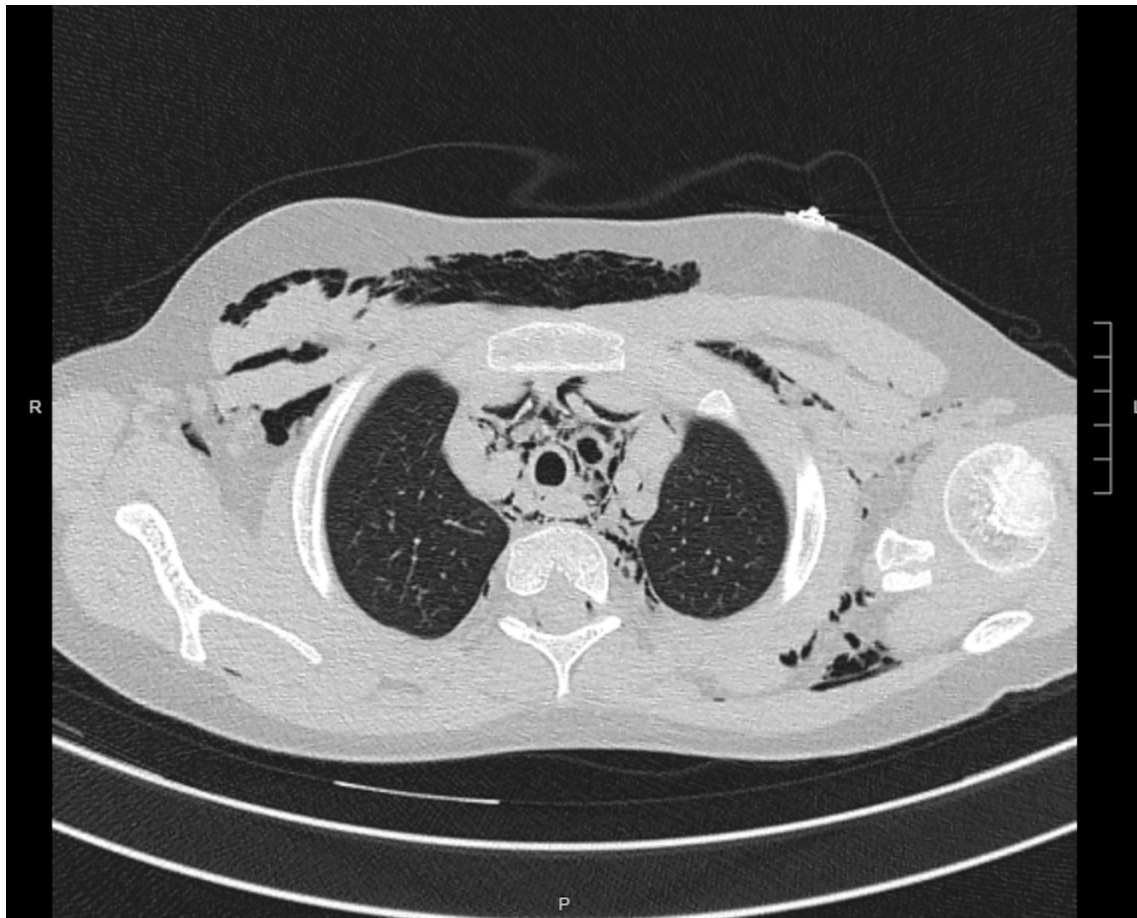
CT shows the presence of air in all recesses of the mediastinum and in vertebral canal in the epidural space.
